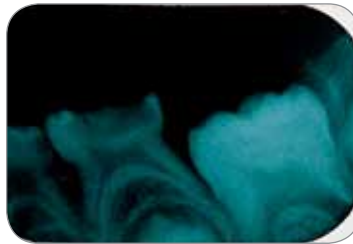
Radiograph demonstrating presence of secondary dentin after silver nitrate followed by fluoride varnish protocol.
